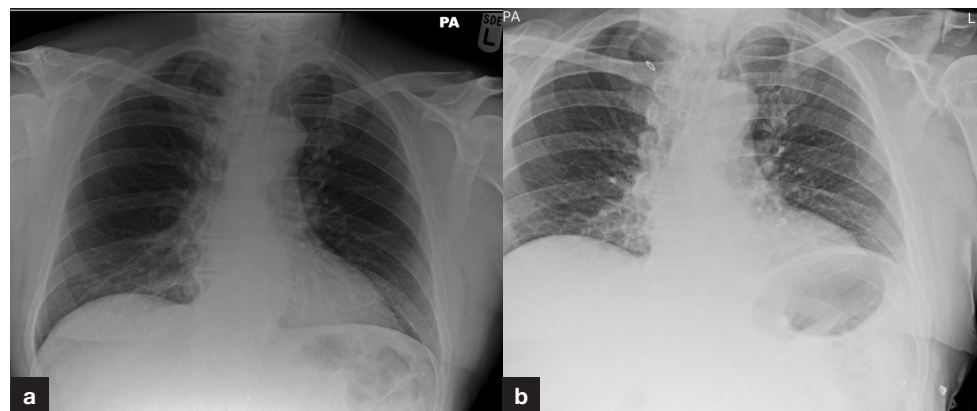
Chest X-ray appearance (a) historic film for comparison and (b) on admission.
